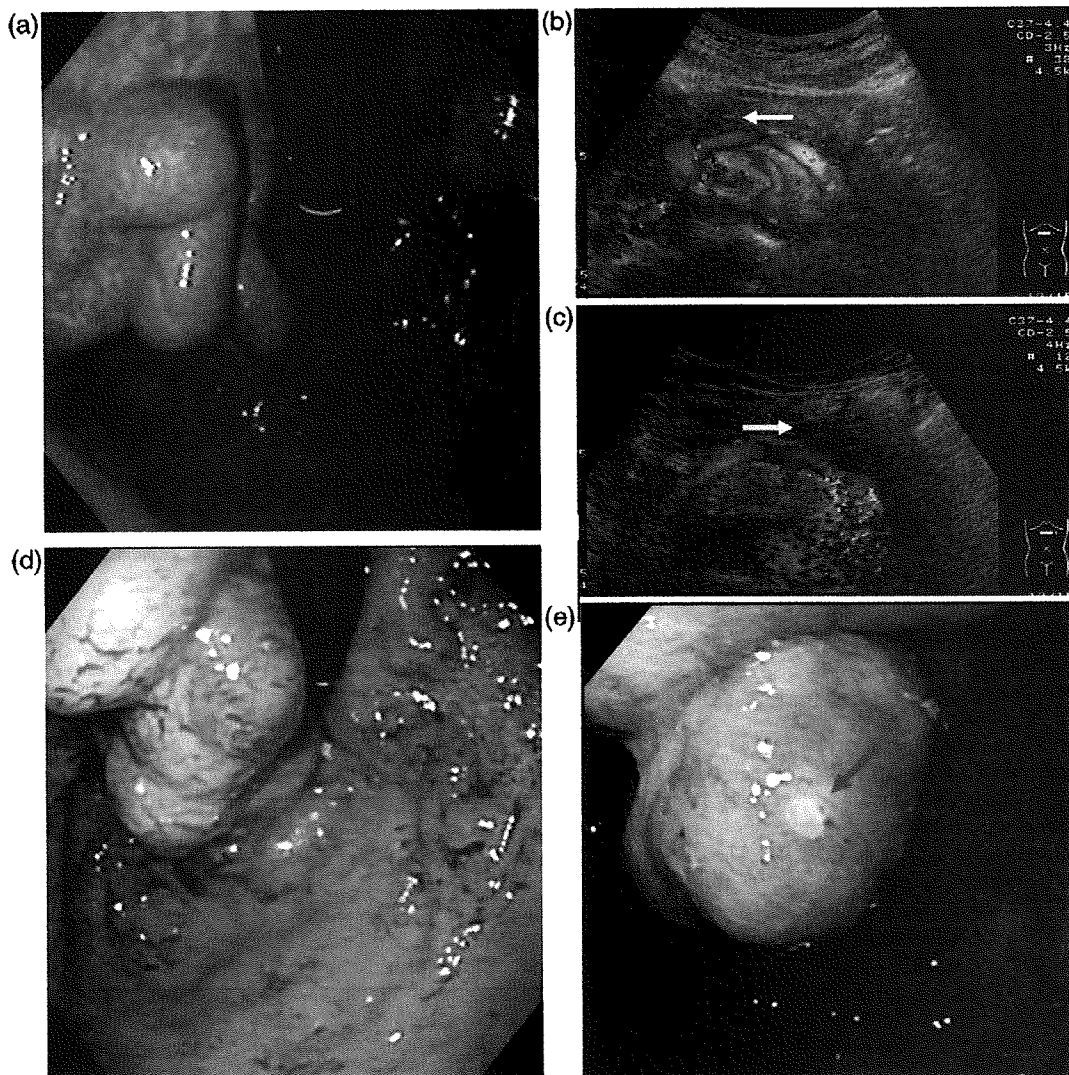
64-year-old male, cirrhotic patient with FV. (a) Endoscopic findings on July 30th, 1997. Endoscopy showed medium-sized FV. (b) Doppler US findings by transverse scan on July 30th, 1997. Flow direction of SV was forward (arrow, flow direction). (c) Doppler US findings by transverse scan on February 19th, 2001. Flow direction of SV was reversed (arrow, flow direction). (d) Endoscopic findings on March 15th, 2001. (e) Endoscopic findings on March 15th, 2001. Bleeding from gastric fundal varices (arrow; bleeding point) was noted, after 25 days of the last Doppler US examination. FV, gastric fundal varices; SV, splenic vein.
